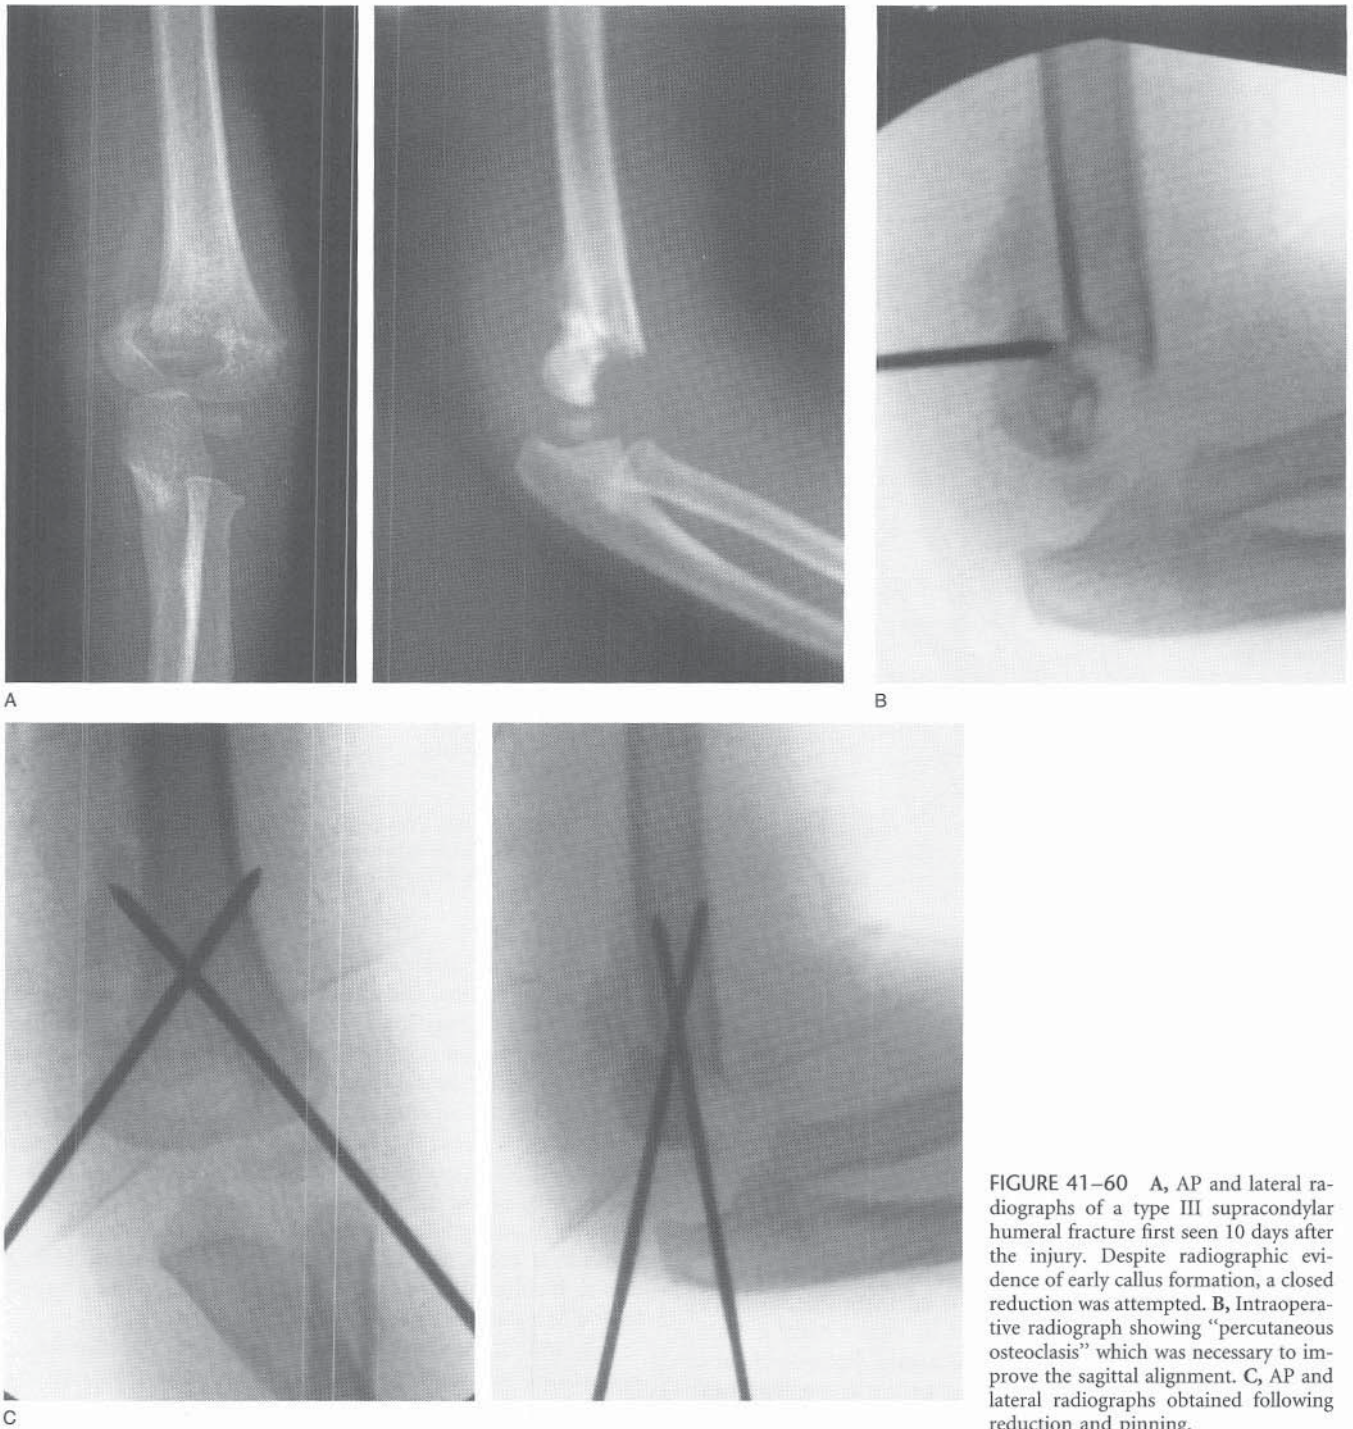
A, AP and lateral radiographs of a type III supracondylar humeral fracture first seen 10 days after the injury. Despite radiographic evidence of early callus formation, a closed reduction was attempted. B, Intraoperative radiograph showing “percutaneous osteoclasis” which was necessary to improve the sagittal alignment. C, AP and lateral radiographs obtained following reduction and pinning.
